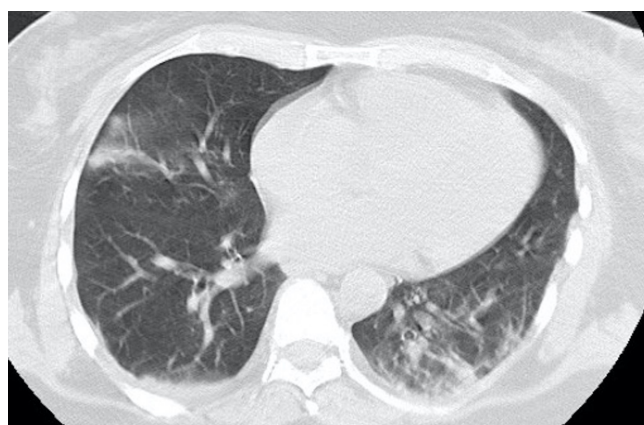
Non contrast chest CT showing subpleural – Multifocal bilateral ground-glass opacities and consolidation of the basal and posterior aspect of the left lung, suggestive of viral pneumonia.
